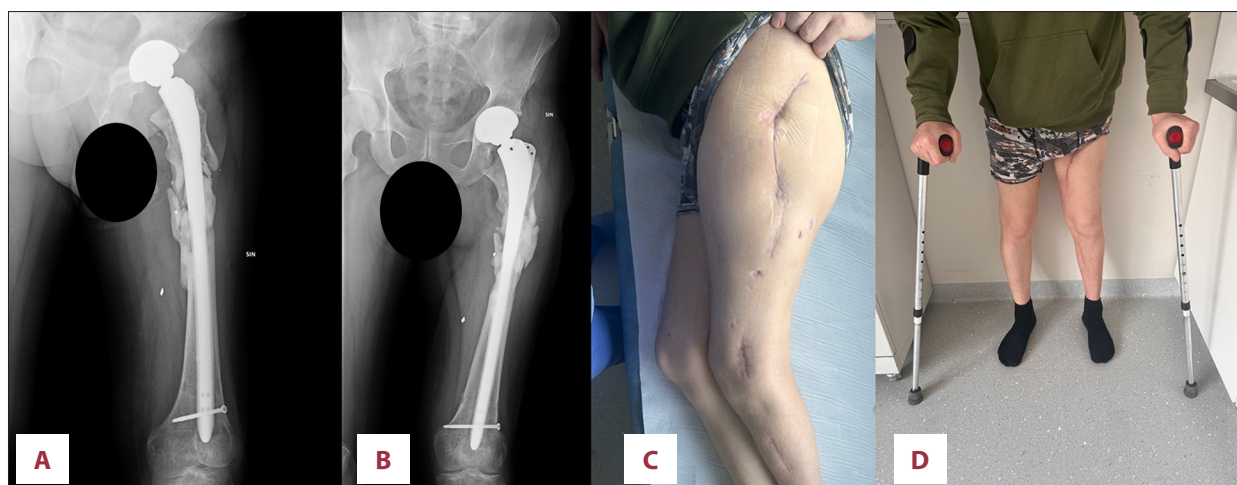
Clinical and radiographic outcome. X-rays (anteroposterior [A], lateral [B]) demonstrating the results of hip arthroplasty without signs of implant loosening. [C] Clinical photograph showing postoperative wounds. [D] Clinical photograph presenting final results with the patient partial weight-bearing with 2.2-cm leg shortening.
